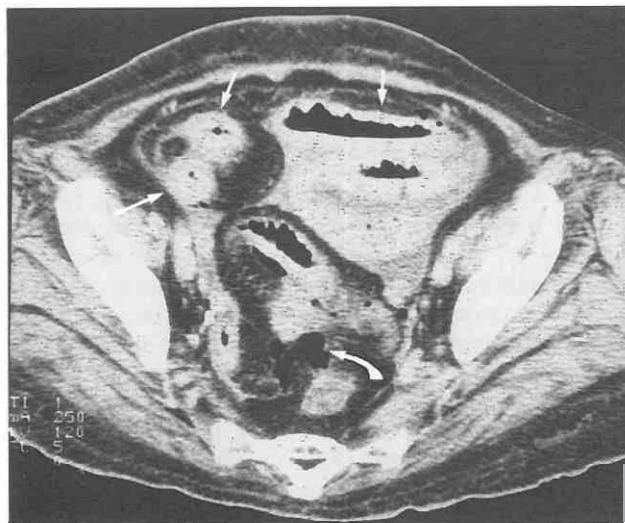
Chemotherapy-induced enteropathy with bowel necrosis and perforation in a patient receiving chemotherapy for leukemia. CT scan shows bowel wall thickening (*arrows*) of the ileum with free gas (*curved arrow*) in the pelvic cavity. Note the intraperitoneal fluid collection, which proved to be hemoperitoneum at surgery. (From Rha SE, Ha HK, Lee SH, et al: CT and MR imaging findings of bowel ischemia according to the various primary causes. *Radiographics* 20:29-42, 2000.)
